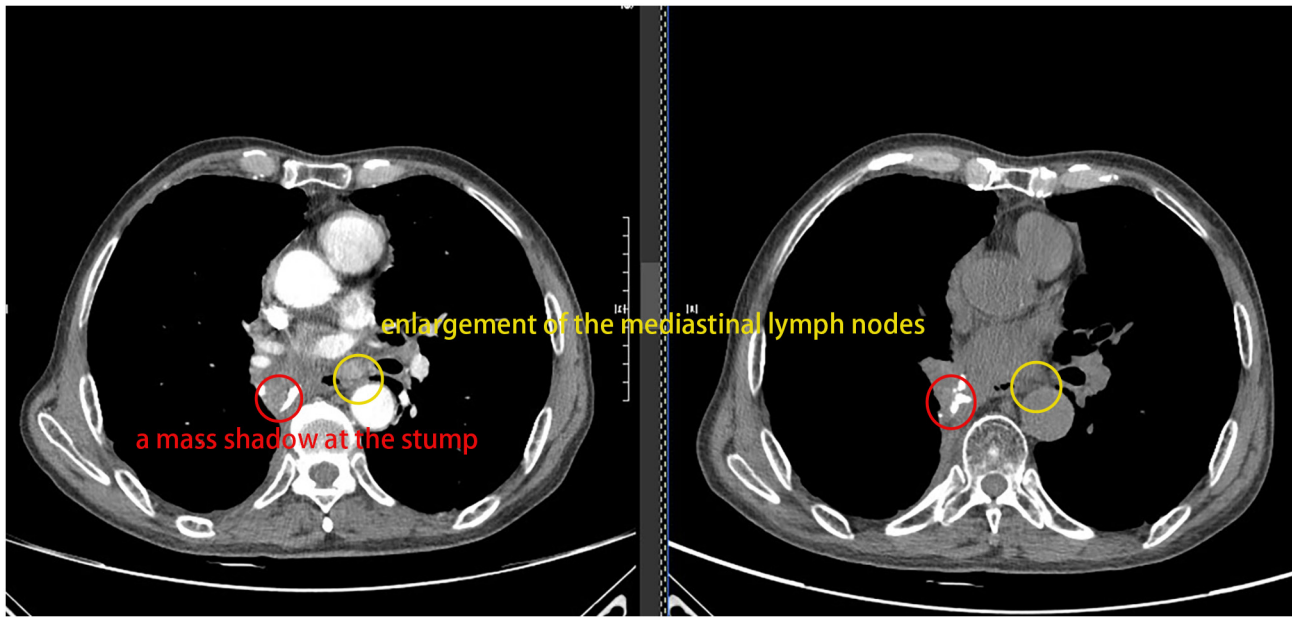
Clinical examination images. CT images of the patient from October 2024 (left) and November 2024 (right), respectively. By comparing these two images, it can be seen that there is no significant progressive change in the shape, size or other aspects of the mass-like shadow at the stump of the right lung after surgery (marked with a red circle); meanwhile, through observation of the CT images from October and November, the phenomenon of lymphadenopathy in the mediastinal region can be clearly observed (marked with a yellow circle).
